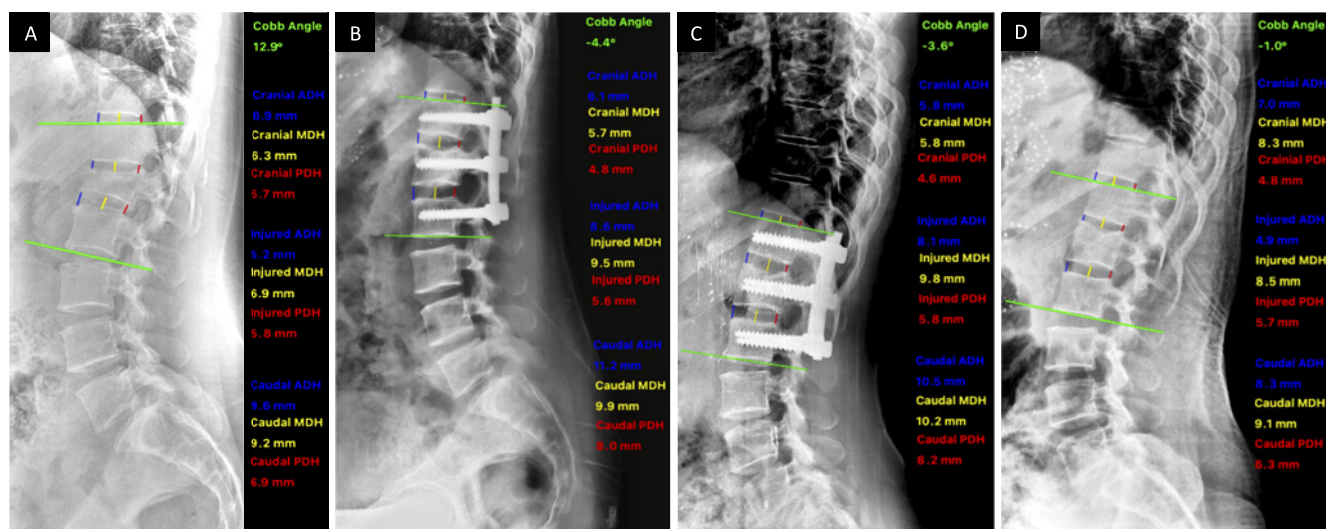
A 25-year-old female with fracture L1 (A3). (A) Preoperative lateral radiograph. (B) Immediate postoperative lateral radiograph after short segment fixation. (C) Lateral radiograph at recruitment (1-year post-fixation). (D) Lateral radiograph at the latest follow-up after metal removal. ADH, anterior disc height; MDH, middle disc height; PDH, posterior disc height
